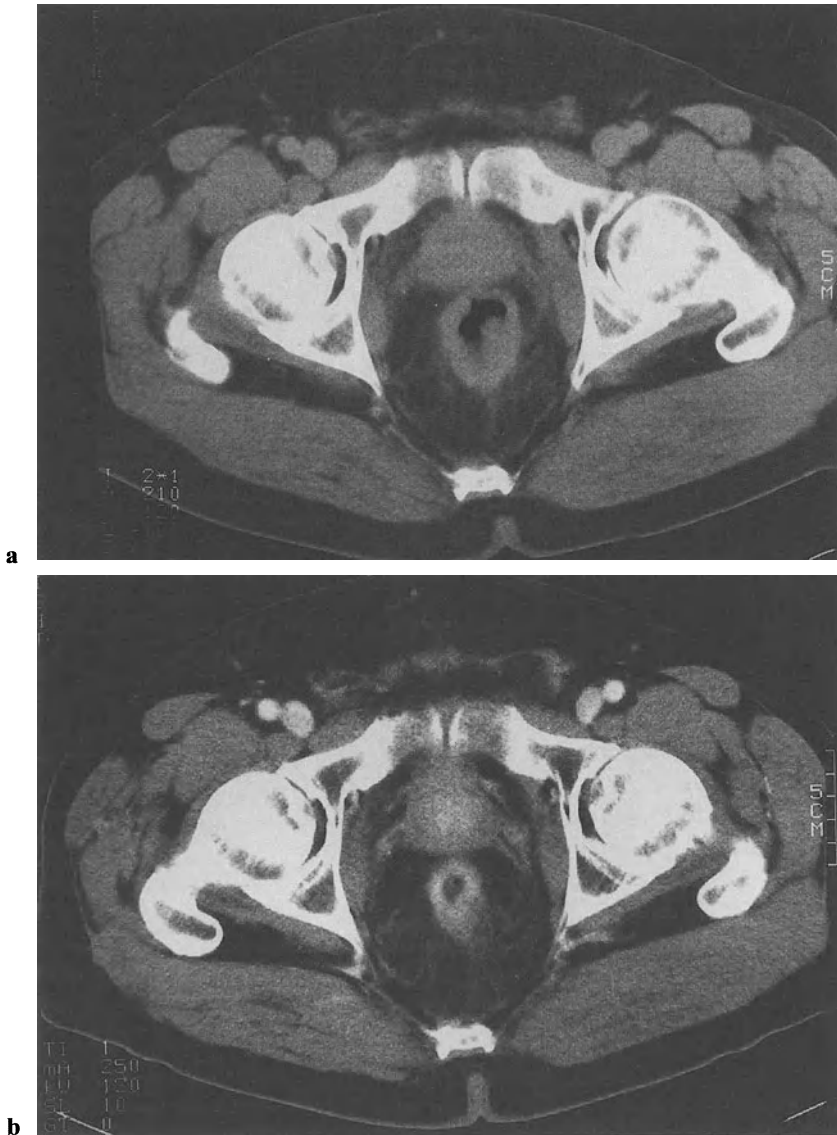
CT scans of a rectal carcinoma before (a) and after (b) preoperative radiochemo-thermotherapy. Clear decrease in tumor size and wall thickness; seminal vesicles easier to demarcate from surroundings
